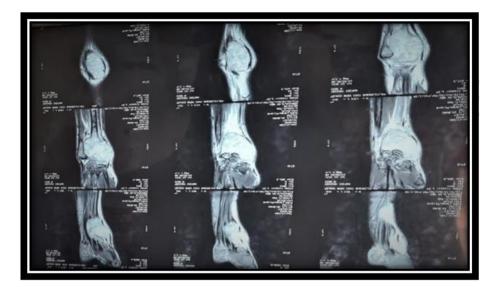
The MRI showing the extension of the tumor to the soft tissue of the wrist
